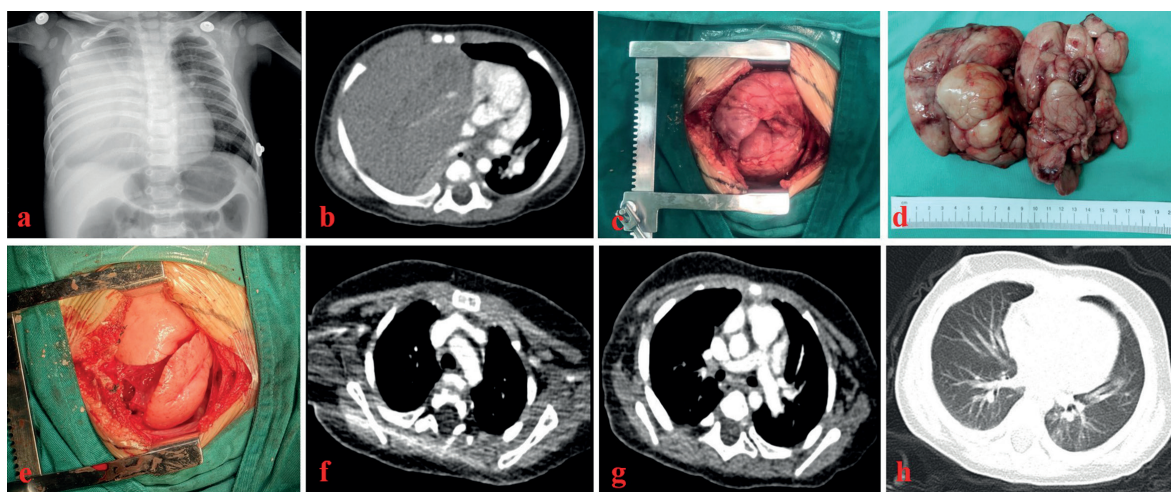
a. Chest X-ray showed a large intrathoracic soft tissue shadow predominantly on the right side, involving most of the right hemithorax. b. Thoracic contrast-enhanced CT detected a solid predominantly hypodense, heterogeneous, hypervascularized soft tissue mass in the right thoracic cavity, significantly compressing the right lung with complete atelectasis and compressing the heart and large blood vessels with mediastinal shift towards the left. c. Exploratory thoracotomy found that a giant mass originating from the mediastinum filling most of the right thoracic cavity, pushing the right lung backwards and upwards. d. The mass was lobulated, fatty and soft in texture with clear boundary and complete capsule, measuring about $17 \times 11 \times 4$ cm and 240g in weight. e. After resection of the whole mass, the right lung immediately re-expanded well with normal function. f. Four months after second operation, thoracic contrast-enhanced CT detected no recurrence and residual of lesion in the mediastinum or thoracic cavity. g. Ten months after second operation, thoracic contrast-enhanced CT also detected no recurrence and residual of lesion in the mediastinum or thoracic cavity. h. The patient's right lung expanded well 4 months after his second operation.
